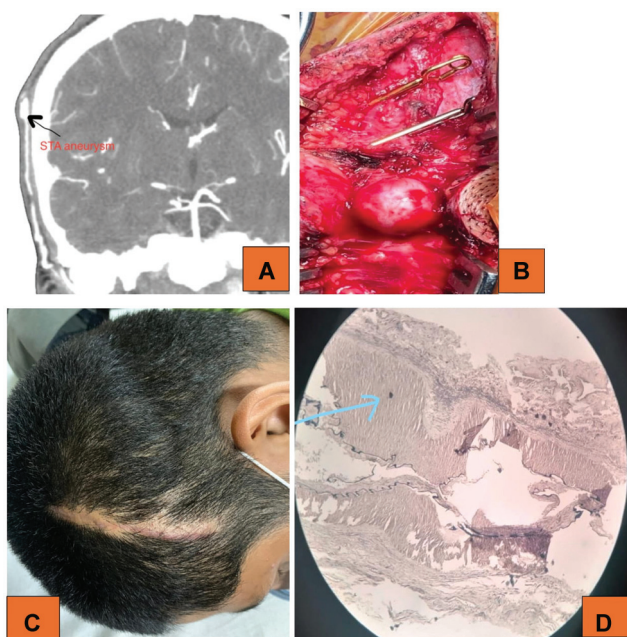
(A) Computed tomography angiography (CTA) showing a right superficial temporal artery (STA) aneurysm. (B) Intra-op photograph with the aneurysm sac totally dissected out prior to excision. (C) Postoperative scar with the incision mark. (D) Elastic Van Gieson 20X: section showing intact tunica intima with hypertrophy in the muscular layer.
